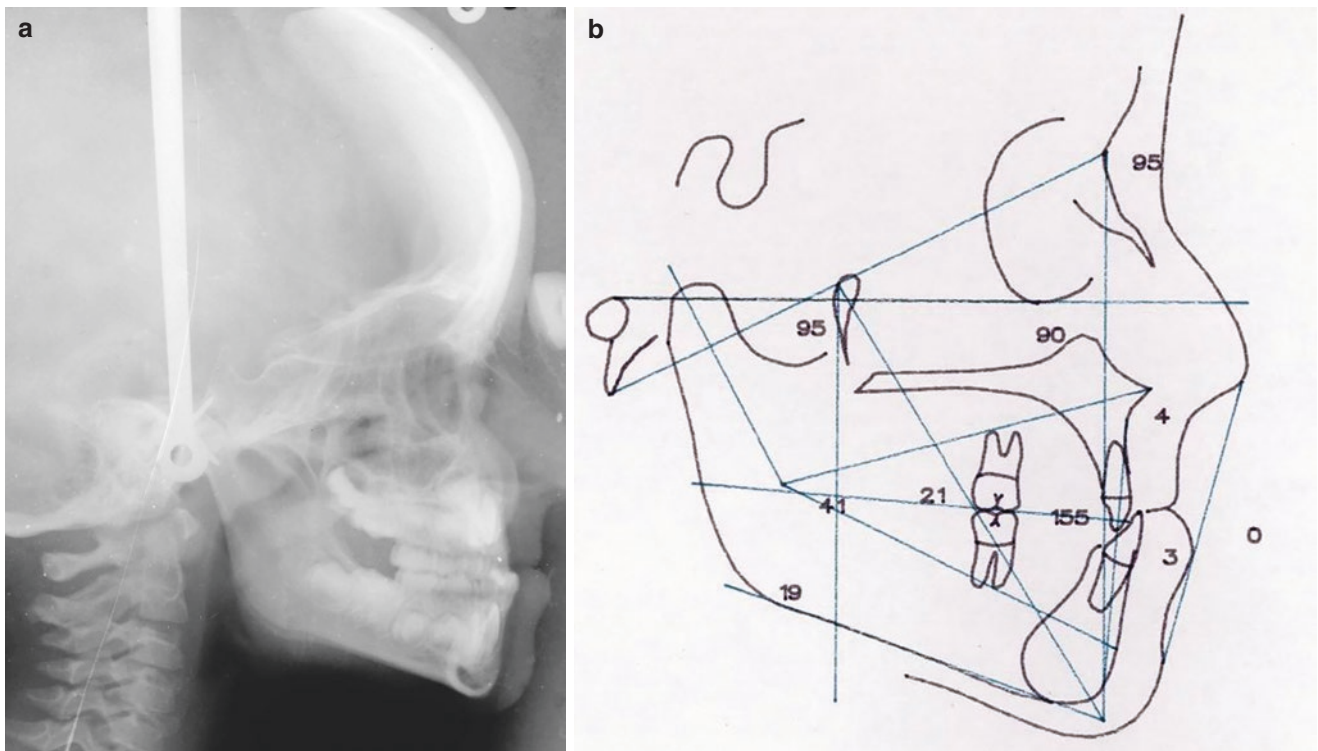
(a, b) Pre-treatment lateral radiograph and Ricketts analysis
